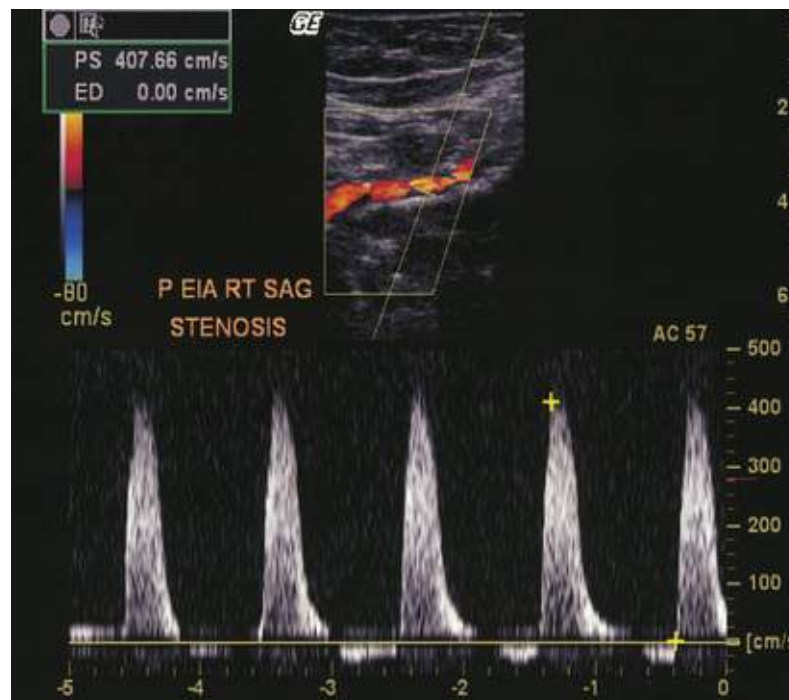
Duplex ultrasonogram of the external iliac artery. The upper image is a color image of the artery in which there is heterogeneity and desaturation of color, indicative of high-velocity flow through a stenosis. The lower image is a recording of the pulse Doppler velocity sampled from the right external iliac artery. The peak velocity of 350 cm/sec is elevated. These features are consistent with a significant stenosis.
